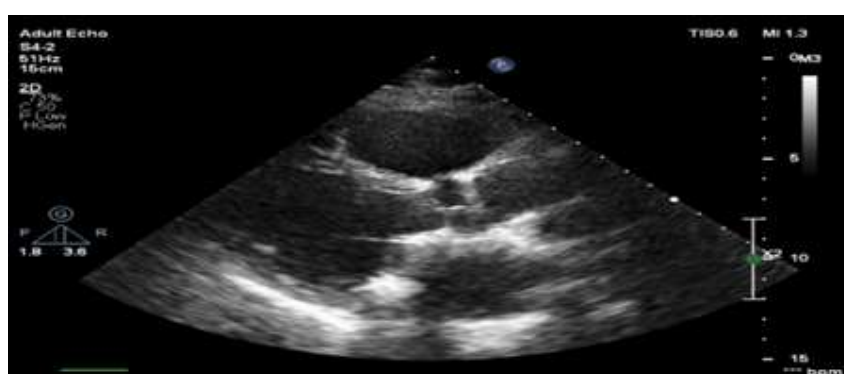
Preoperative transthoracic echocardiography. Fixed medial leaflet of prosthetic mitral valve (white arrow), in comparison to the other leaflet (black arrow).
